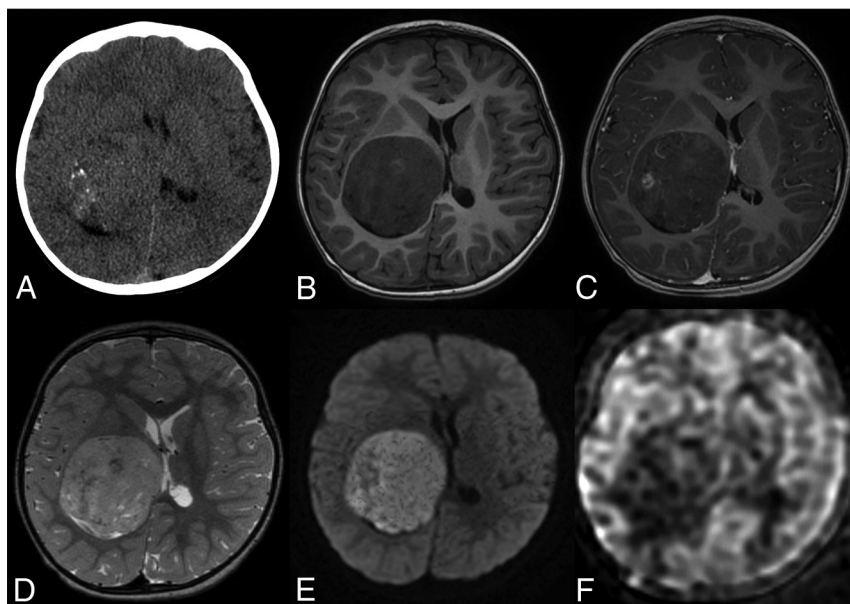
Brain imaging of patient 11. Axial plane image on CT (A) shows a right thalamic mass with microcalcifications. The tumor displays hypointensity on the T1-weighted image (B), hyperintensity on the T2-weighted image (D), and weak nodular enhancement after contrast media injection (C). An intratumoral vessel is seen (C). Diffusion signal is high (E) with low ADC. Cerebral blood flow (F) is low (maximum, 46 mL/min/100 g) within the tumor.
